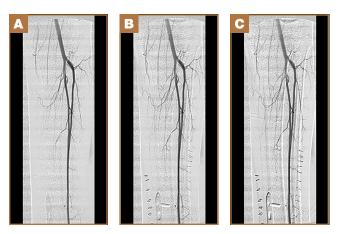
Angiogram confirms 1-vessel run off in distal leg. (A–C) Time-sequenced radiographs after administration of contrast.
